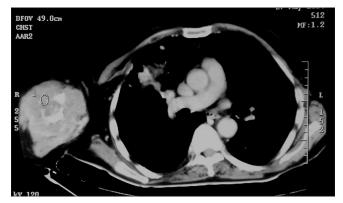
Fracture of right humerus with adjacent soft tissue swelling visible in computed tomography thorax
